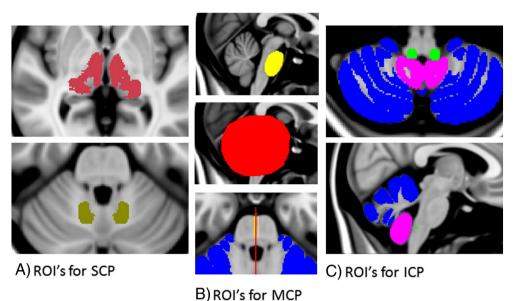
Regions of interest used for tractography, overlaid on the 1 mm T1-weighted MNI template. A. Regions of interest for estimating the superior cerebellar peduncle (SCP). Top panel: thalamic subnuclei from the Oxford Thalamic Connectivity Atlas (Behrens et al., 2003), pictured in dark red, were used as waypoint and stop masks. Bottom: right and left dentate nuclei depicted in khaki green were used as seed masks. B. Regions of interest for estimating the middle cerebellar peduncle (MCP). The belly of the pons was segmented in the sagittal plane at X = 88 for the right MCP (yellow) and X = 91 for the left MCP (orange), which were used as seed masks. The Probabilistic Atlas of the Cerebellum (Diedrichsen et al., 2011), thresholded at 50%, was chosen as a waypoint and stop mask (blue). An exclusion mask was drawn in the mid-sagittal plane at X = 89 (red) to prevent streamlines from crossing to the contralateral hemisphere. C. Regions of interest for the inferior cerebellar peduncle (ICP). Seed regions in the restiform body (bright green) were placed at Z = 24 based on the 1 mm FA skeleton. Again, the Probabilistic Atlas of the Cerebellum (Diedrichsen et al., 2011), thresholded at 50%, was chosen as waypoint and stop region (blue) and the mid-sagittal exclusion mask was used. A second exclusion mask was located in the tonsils to prevent streamlines from crossing the cerebello-medullary fissure (pink).
